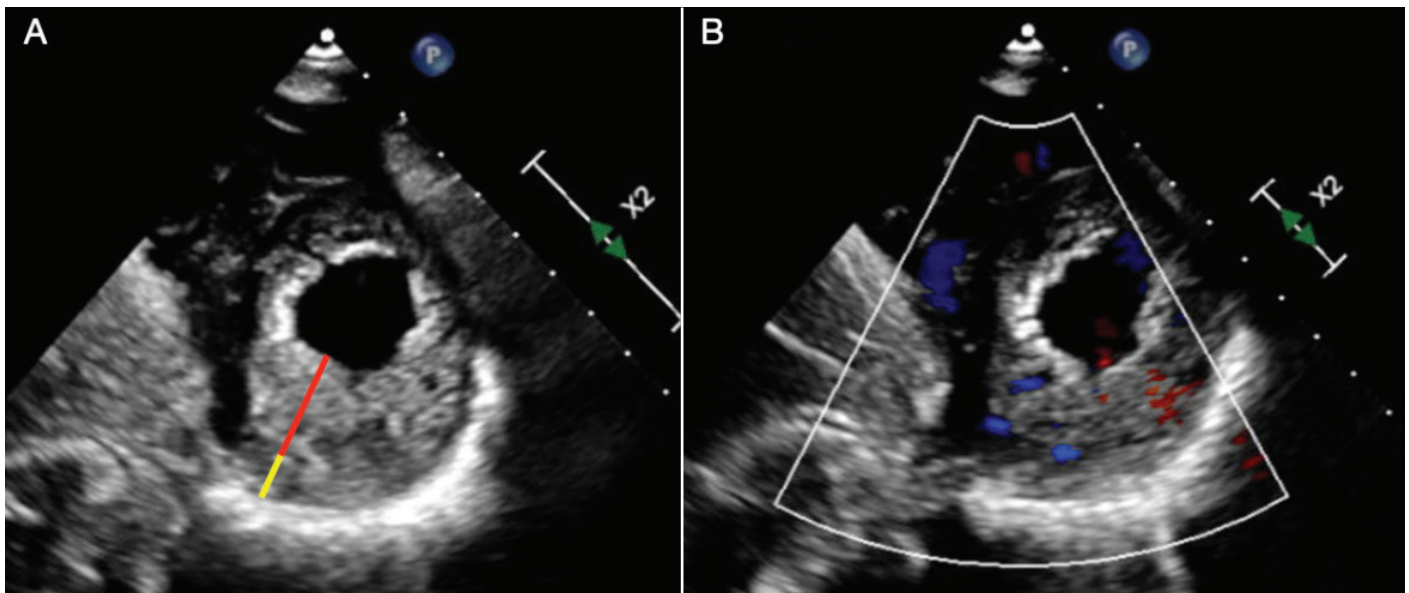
Jenni Criterion with Transthoracic echocardiography: (A) Noncompacted layer (red line) / compacted layer (yellow line) > 2 in the short-axis view at end-systole, with trabeculation predominance in the mid and apical segments. (B) Blood flow in intertrabecular recesses visualized with color Doppler.
